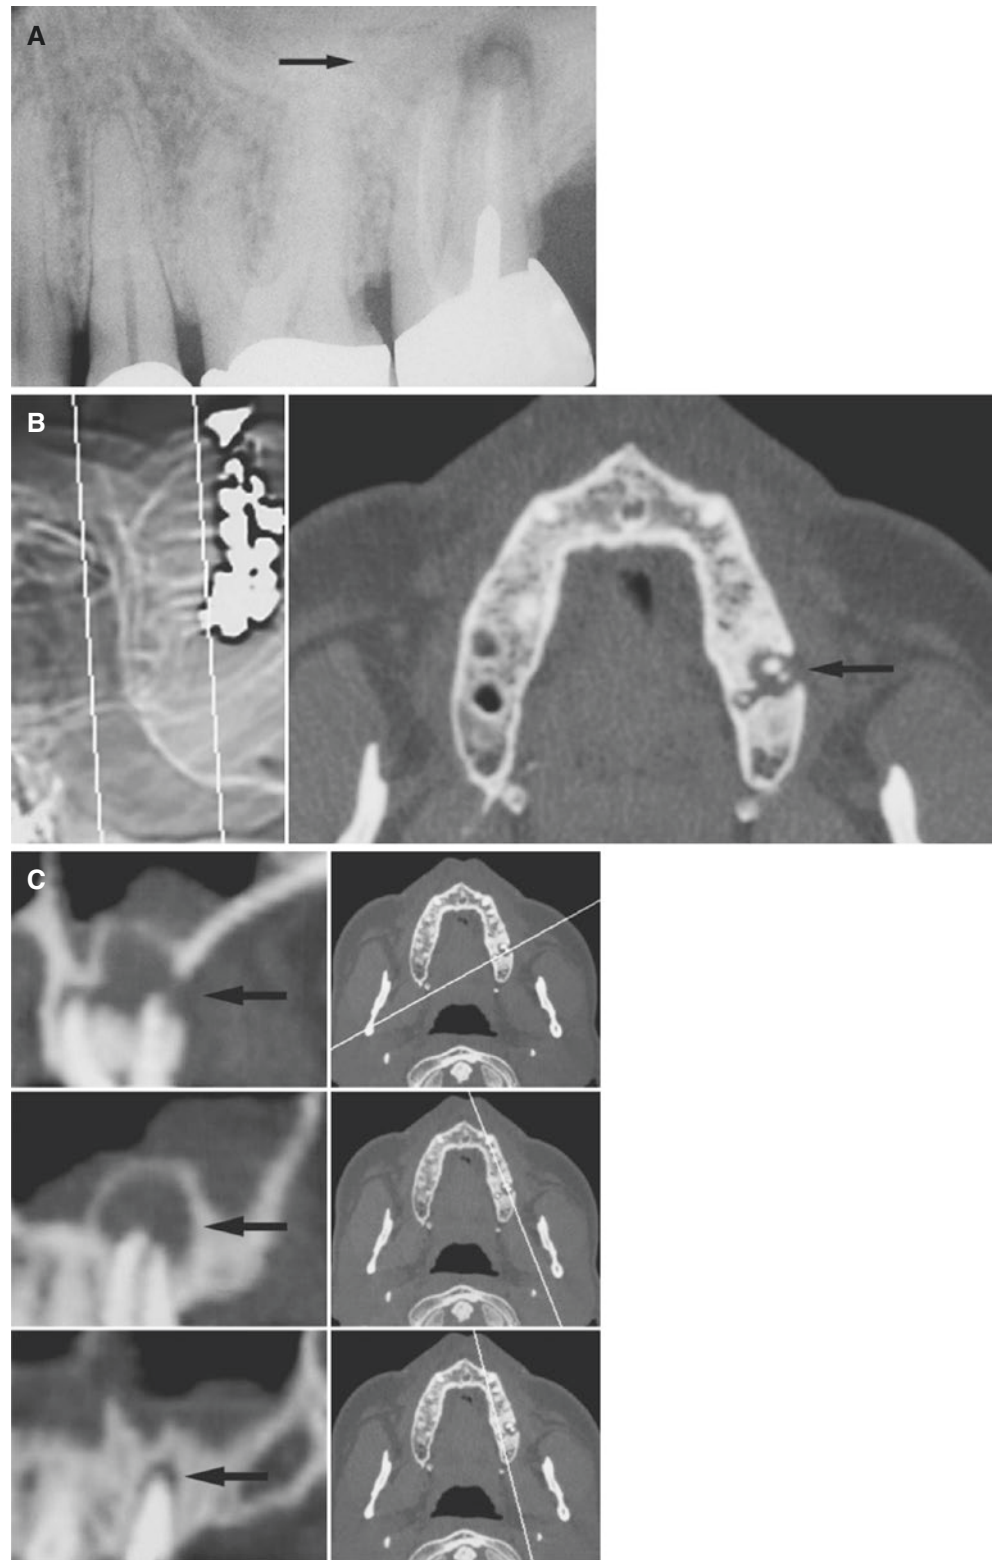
Apical periodontitis; 50-year-old male with variable pain from the left maxilla. (A) Intraoral view shows apical radiolucency of the second molar, apparently only at palatal root (*arrow*). Involvement of different roots needs to be assessed to decide whether or not apicoectomy can be successfully performed. (B) Axial CT image (scout view with scanning direction and field to avoid amalgam artifacts from teeth) shows a larger radiolucency (*arrow*) at buccal roots than at palatal root of the second molar, with surrounding bone sclerosis. (C) Oblique coronal CT image (*upper row*) (according to cursor line in reference image) shows cystic process with destroyed buccal cortex (*arrow*). (C) Oblique sagittal CT image (*middle row*) (according to cursor line in reference image) shows cystic process with intact cortical outline (*arrow*). (C) Oblique sagittal CT image (*lower row*) (according to cursor line in reference image) shows small radiolucency (widened periodontal space) at palatal root (*arrow*), with surrounding sclerotic bone. Note some antral mucosal thickening
